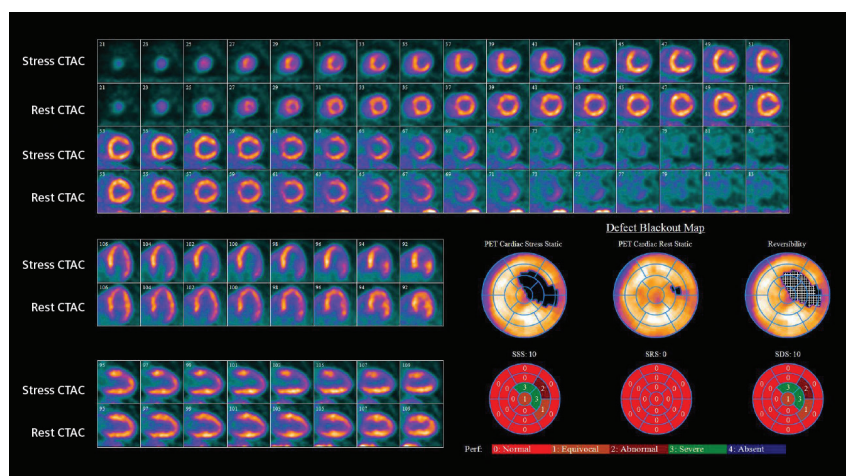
Stress/rest  $^{82}\text{Rb}$  PET/CT MPI shows a severe, but reversible perfusion defect in the anterolateral wall, adjacent to the apex.
